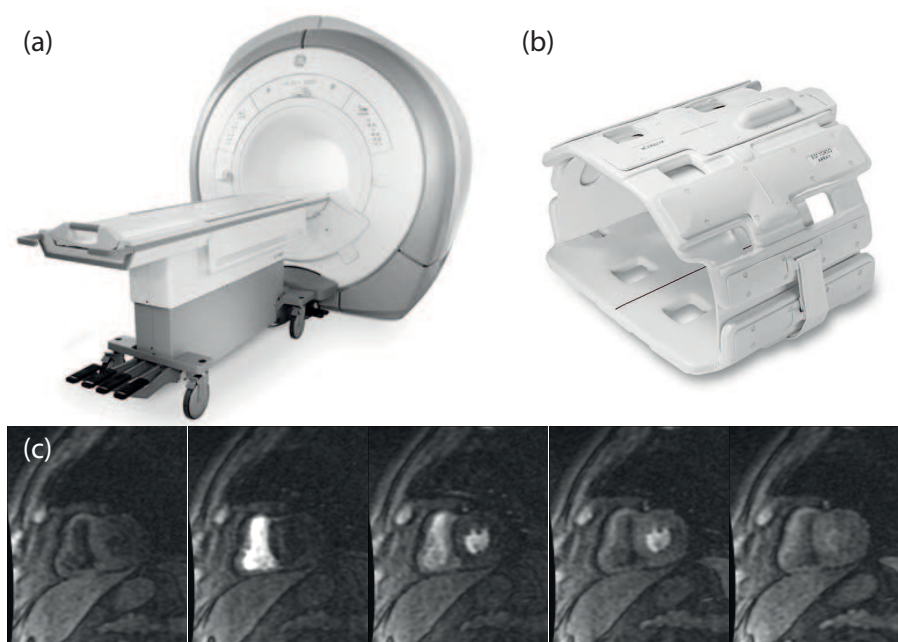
Cardiac magnetic resonance imaging (MRI). Signa HDxt 1.5T scanner (a) and an eight-element phased-array receiver coil (b) (GE Medical systems, Milwaukee, Wisconsin USA). (c) Example of stress perfusion MRI sequence.
